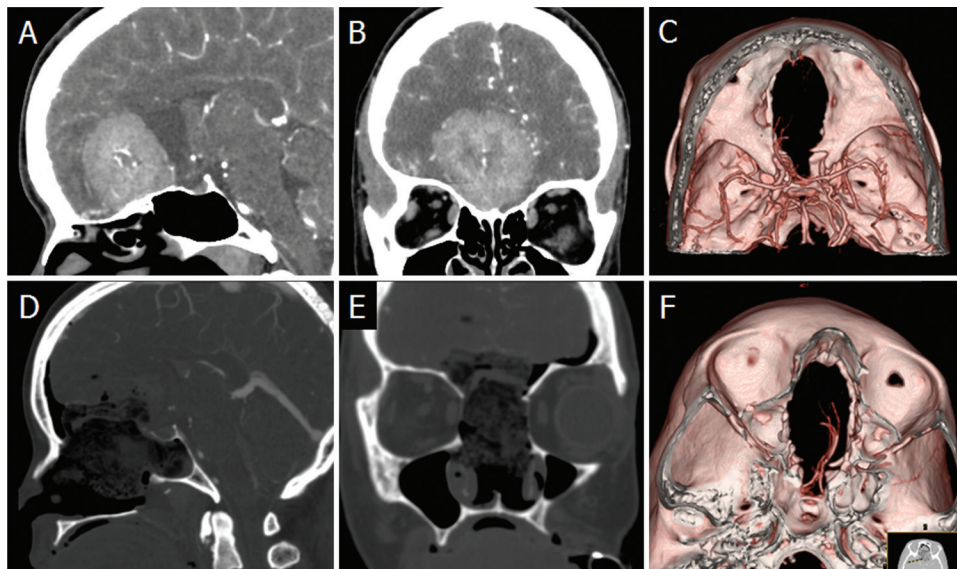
Case 1. A and B: Preoperative sagittal (A) and coronal (B) contrast-enhanced CT reconstructions demonstrating a large olfactory groove meningioma with hyperostosis of the cribriform plate. D and E: Postoperative sagittal (D) and coronal (E) contrast-enhanced CT reconstructions demonstrating the extent of bone resection extending from the back of the frontal bone to the sella turcica in the sagittal view, and from medial orbit to medial orbit in the coronal view. Note that the patient did not have a frontal sinus. C and F: Postoperative 3D reconstructed CT angiograms demonstrating multiple views of the anterior skull base defect and surrounding vasculature after a transcribriform approach. C: View looking from above demonstrating a large anterior skull base defect. F: View looking up from below mimicking the endonasal endoscopic view of the ventral anterior skull base defect with the anterior cerebral arteries in the distance.
